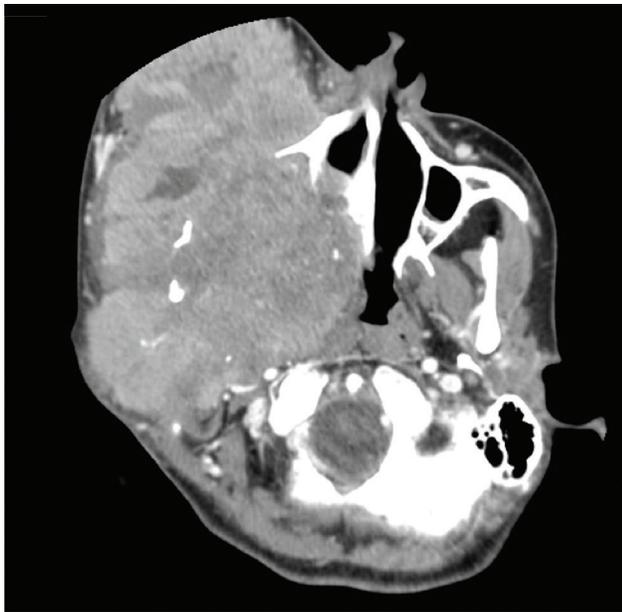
Axial contrasted CT (computed tomography) scan of patient from Case Study 46-3, revealing a large tumor involving the deep and lateral aspects of the parotid gland, the mandible, and the parapharyngeal space.
